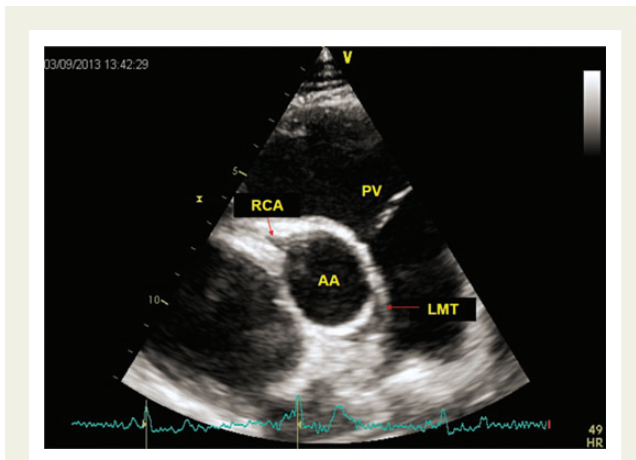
Echocardiographic assessment of coronary origin in an elite basketball player (red arrows), in a modified parasternal short-axis view. This kind of imaging requires an experienced operator and good image quality to confidently identify the ostia and proximal course of the coronary circulation. RCA, right coronary artery; LMT, left main trunk; PV, pulmonary valve; AA, ascending aorta.
